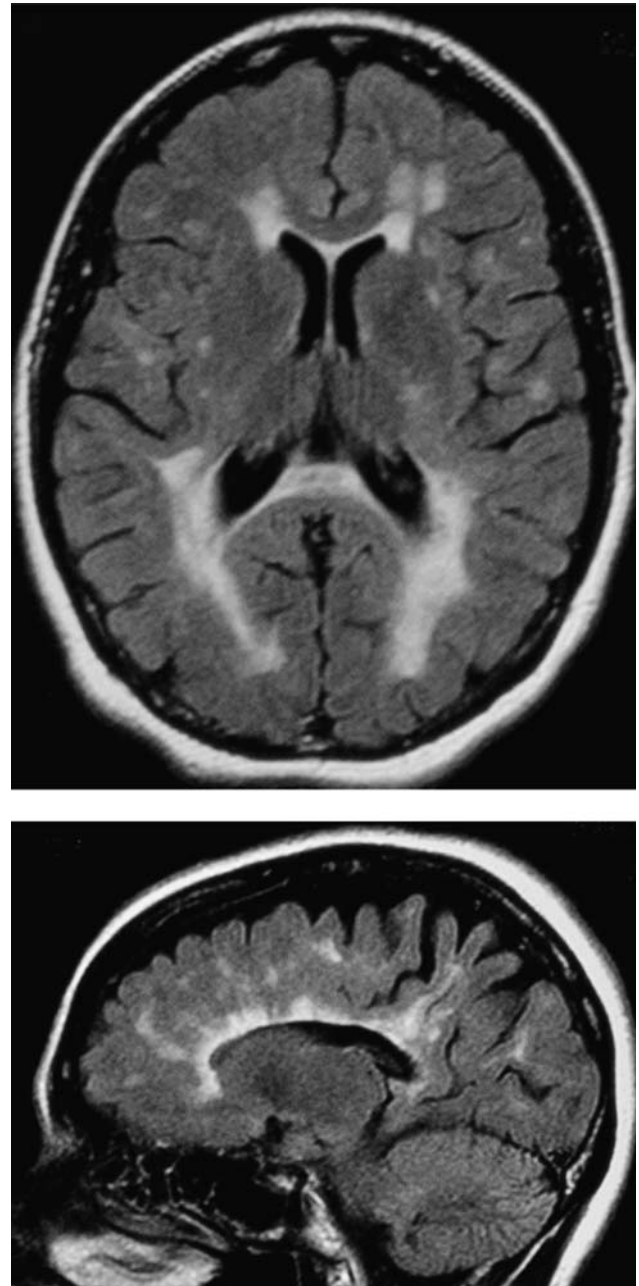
Representative images from brain magnetic resonance imaging scan performed 9 years after N.L.'s diagnosis of multiple sclerosis. Summary of the findings from this and several other scans performed at around the same time: N.L. had mild volume loss for age, and mild loss of callosal volume. There were numerous foci of increased signal intensity throughout the periventricular white matter; some of these foci were confluent, others focal. There were also numerous foci of increased signal intensity throughout the subcortical white matter, corpus callosum, white matter tracts of the corpus striatum, and cerebellum bilaterally. A few foci of increased signal intensity were found in the brainstem and deep gray matter.
